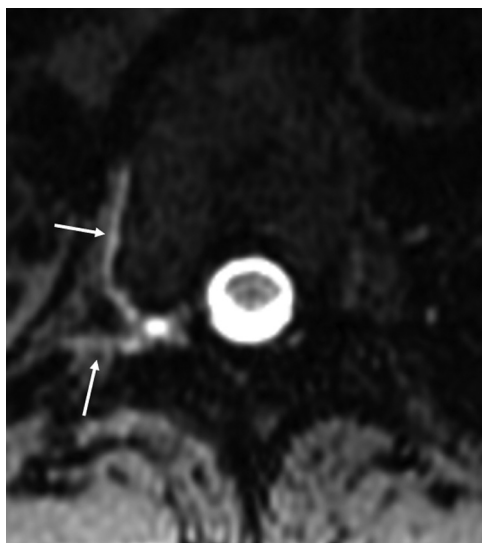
T1-weighted image from a GdM demonstrating a right T7 CVF involving the paraspinous segmental vein and lateral branches (arrows).
